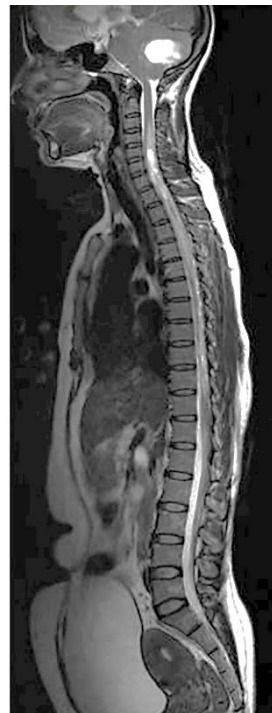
MRI of the brain contrast image showing cystic lesion with enhancing nodule in the left cerebellar hemisphere and cervical spinal cord
